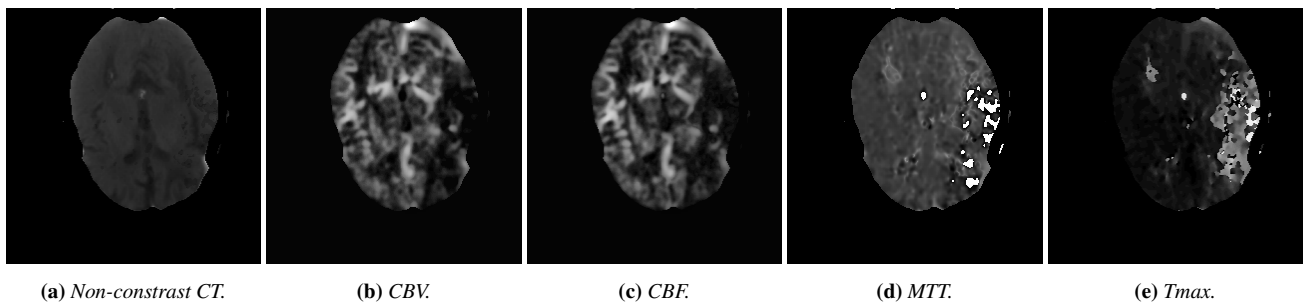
Input modalities in the presented case. a) original CT scan. The remaining modalities are computed based on the b) cerebral blood volume (CBV), c) cerebral blood flow (CBF), d) mean transition time (MTT) and e) time to peak (Tmax).
